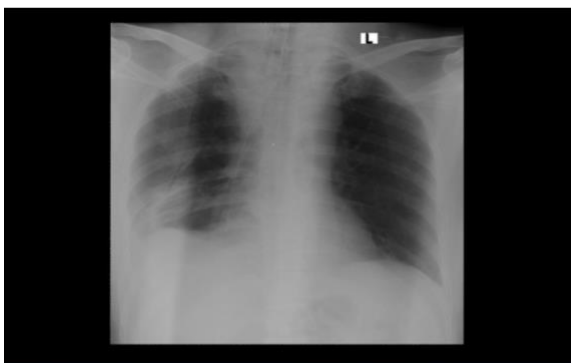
Chest X-ray showed widening of the mediastinum
